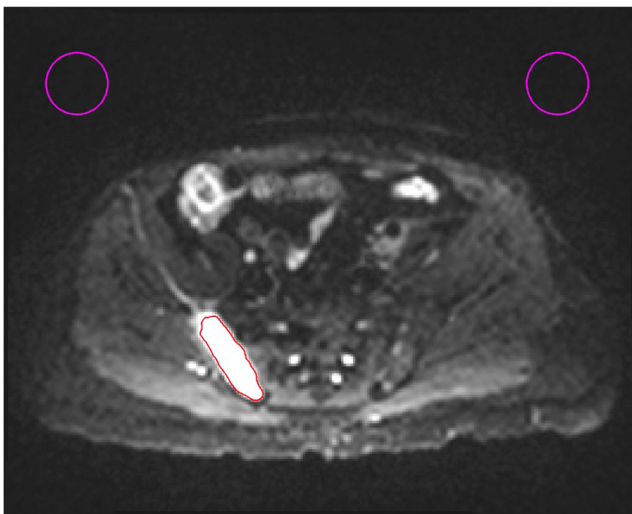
An example of the ROIs drawn (pink) on DWI $b = 50$ s/mm² image to estimate the noise. The lesion is delineated in red. The number of pixels in the ROIs was kept constant across the different matrix sizes used
